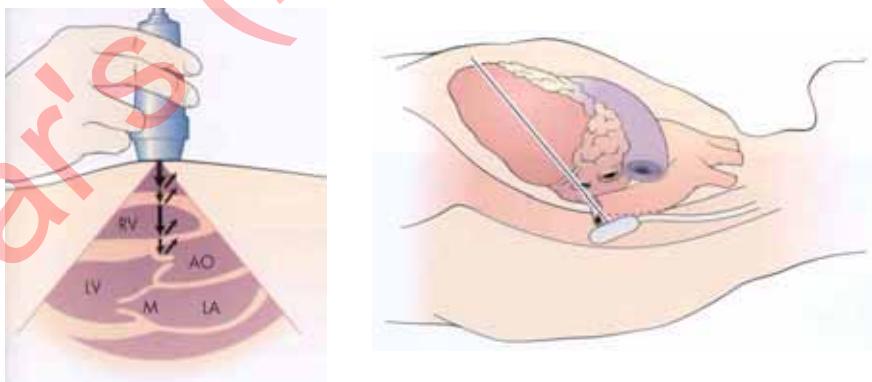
Transthoracic (left) and Transesophageal (right) Echocardiography. Transthoracic and transesophageal echocardiography can be used to evaluate cardiac function and structure. The transthoracic approach is more expedient and can be performed on awake, non-sedated patients. However, the quality of the images may be inferior to those obtained using the transesophageal approach. In addition, transthoracic echocardiography requires that appropriate acoustic windows be identified. In certain patients (patients with chest wall deformities, trauma patients
